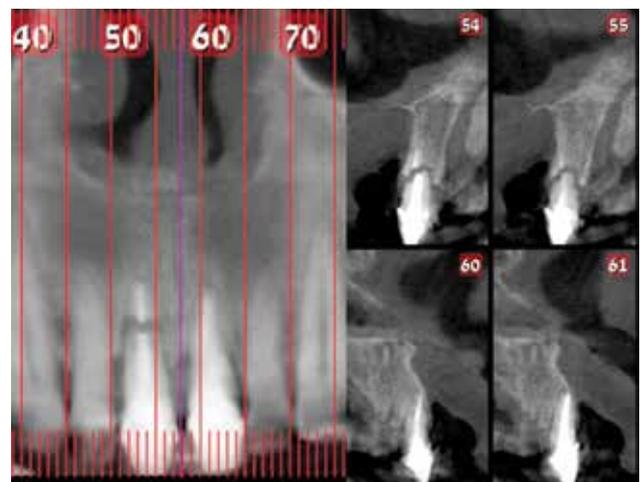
The CBCT depicted a horizontal root fracture at No. 8, considerable bone loss, and very thin or no labial cortical plates at both teeth.
